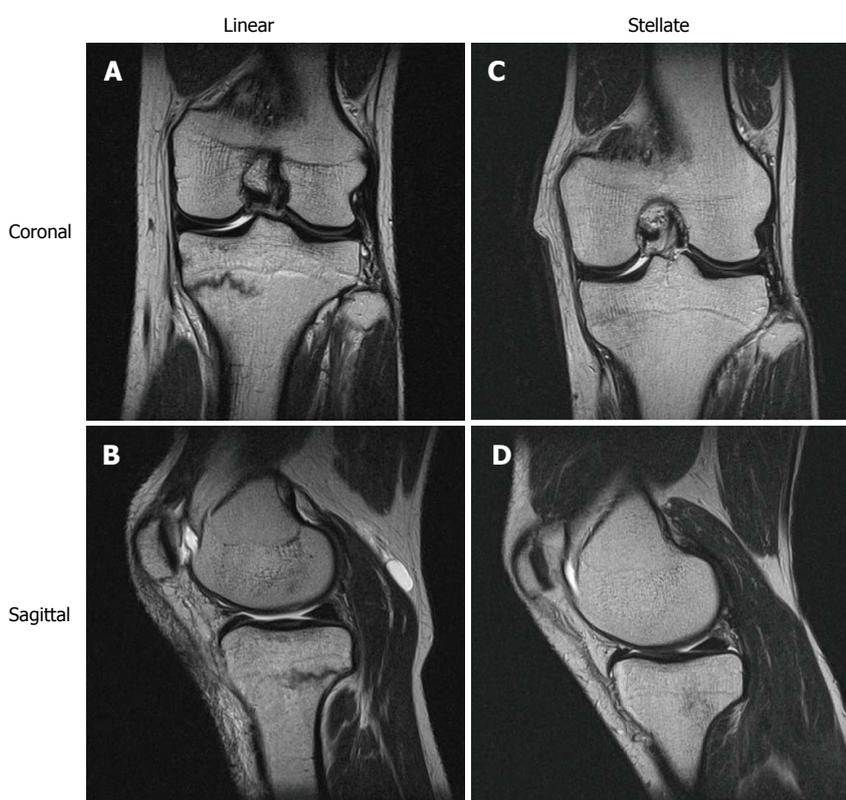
Representative magnetic resonance imaging images of T2-weighted coronal and sagittal views of linear type (A and B) and stellate type (C and D) in stress fractures of the medial tibial plateau.
